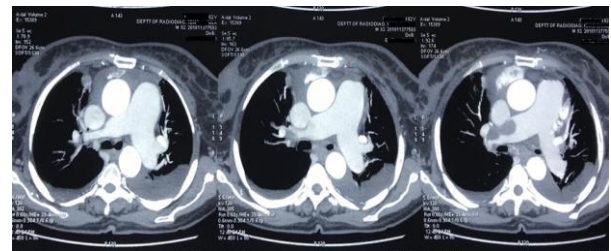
CT showing thrombus in Right pulmonary artery
